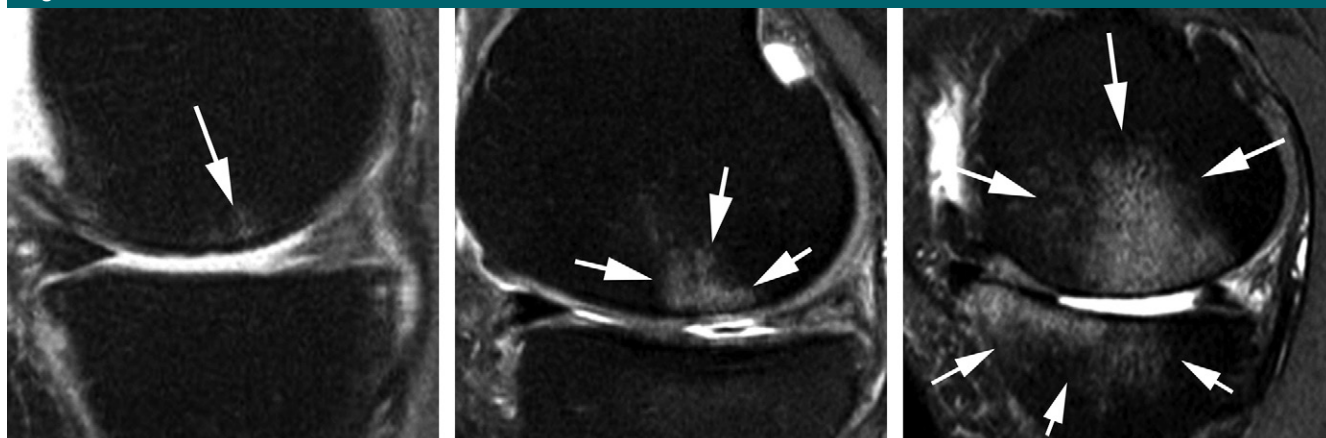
MR images demonstrate BML assessment according to lesion size. (a) Sagittal intermediate-weighted fat-saturated MR image shows a small grade 1 subchondral BML in the central subregion of the medial femur (arrow). (b) Sagittal MR image demonstrates a grade 2 BML (arrows). (c) Sagittal fat-saturated MR image depicts a large grade 3 lesion as diffuse hyperintensity (large arrows). Note the additional diffuse bone marrow changes, also in the anterior and central part of the medial tibia (small arrows).
